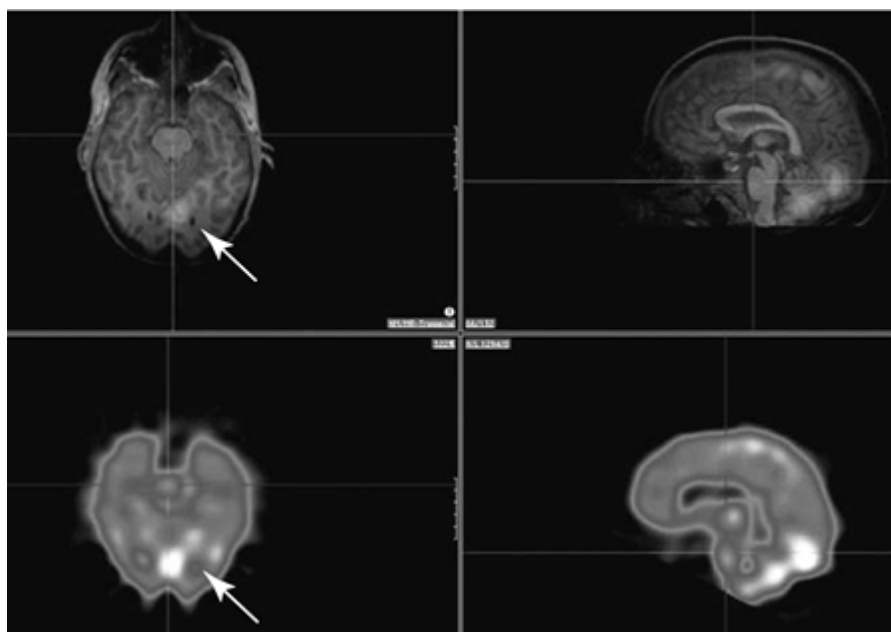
Early injection can suggest areas that should be further investigated. An early injection in a patient with apparent temporal lobe epilepsy suggests that there is early activity in the mesial occipital region. The top panels show the activation coregistered and superimposed over the magnetic resonance imaging anatomy, the lower panels show the single photon emission computed tomography image only.
